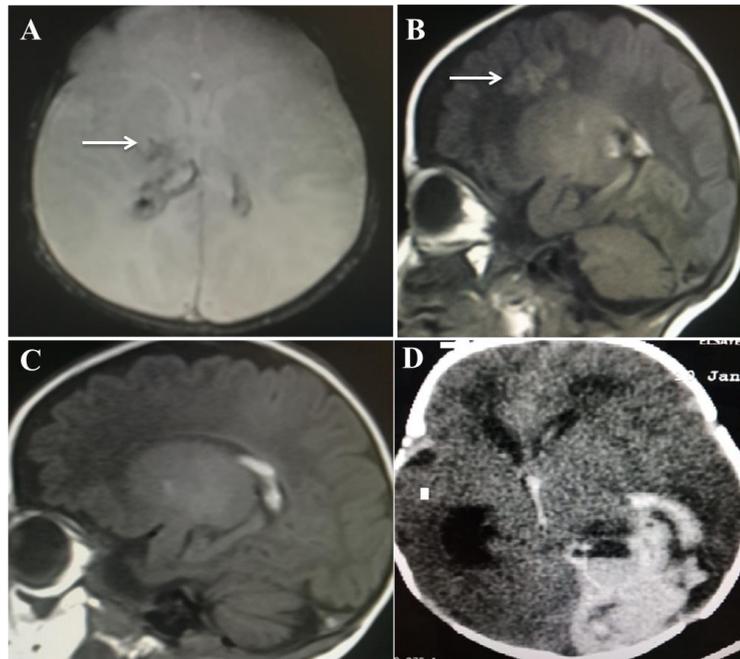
Magnetic resonance imaging A), B), and C) showing axial gradient; sagittal T1 WIs of brain showing grade IV periventricular hemorrhage with parenchymal extensions [arrows]; D) axial computed tomography image showing intraventricular hemorrhage more evident at left lateral ventricle side, as well as within third ventricle with parenchymal extension to left parieto occipital lobes and associated with hydrocephalus and midline shift
